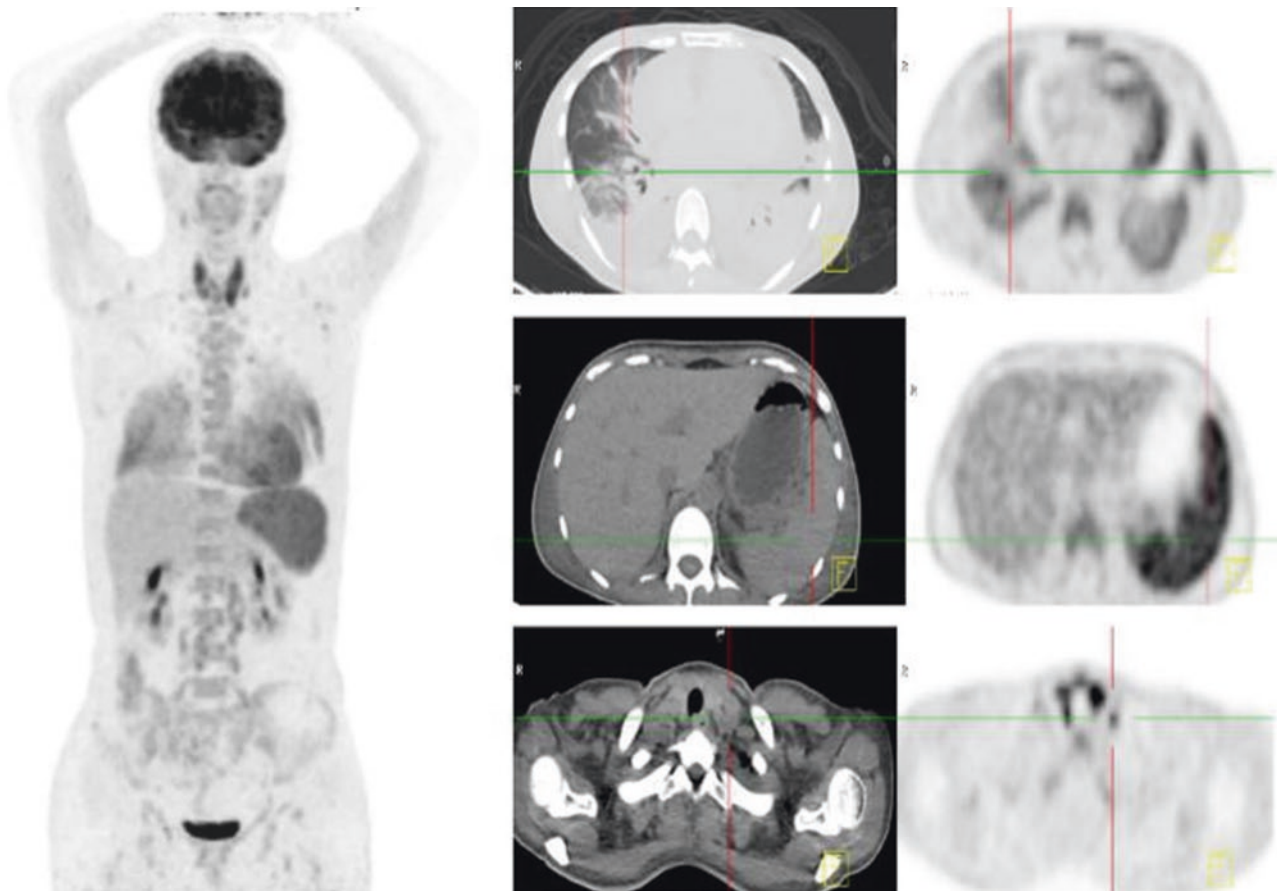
^{18}F -FDG PET/CT image
